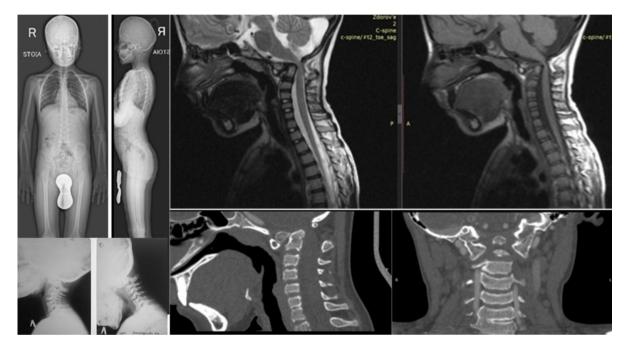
Spinal X-ray image (1a-frontal, 1blateral, 1c -after maximum bending and extension) shows the patient's AAD and C1-os odontoideum dislocation. Sagittal CVJ MRI image (1 d,e) demonstrates the expressed basilar kyphosis with Wackenheim's angle reduced to 99 degrees, and spinal canal stenosis causing spinal-cord compression (minimum sagittal spinalcord size at C2 is reduced to 0.45 mm). MSCT image (1e – sagittal and axial) show a joint forming between the osodontoideum and the posterior part of C1 arch. Anterior C1 dislocation. Right-sided C2-C3 concrescence
